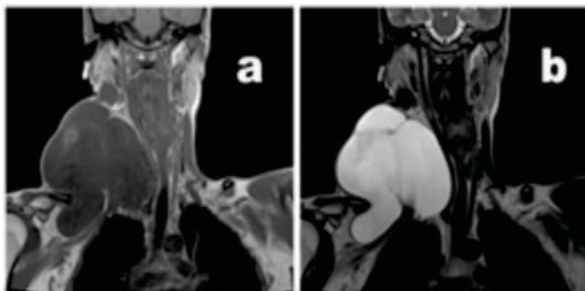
MRI shows well defined T1 hypointense (a), T2 hyperintense (b) multiseptate cystic lesion.
